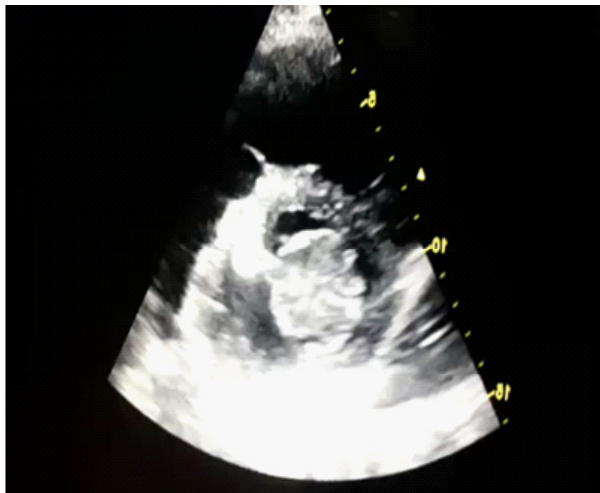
Transthoracic echocardiogram showing a huge left atrial mass
